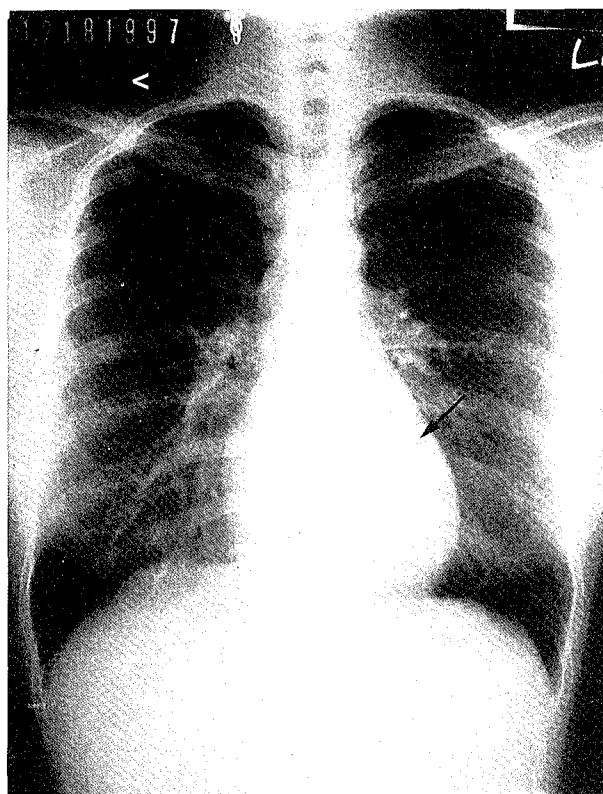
Chest radiograph shows a solitary nodule (arrow), about 2 cm in diameter, in the left lower lobe.
